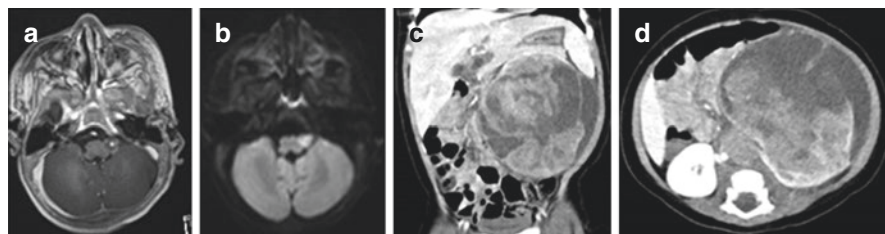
Imaging of Rhabdoid Tumour Predisposition Syndrome. (Patient example from our institution, Neurosurgical Service, KK Women's and Children's Hospital). MRI brain images demonstrating a small lesion at the left medulla with heterogeneous enhancement and restricted diffusion associated with a large heterogeneous left renal tumour seen on CT imaging. (a) Axial T1W + C image; (b) Axial DWI; (c and d) Axial and coronal images of contrasted CT of the abdomen. (MRI: magnetic resonance imaging; CT: computed tomography; T1W + C: T1 weighted with contrast; DWI: diffusion weighted image)
